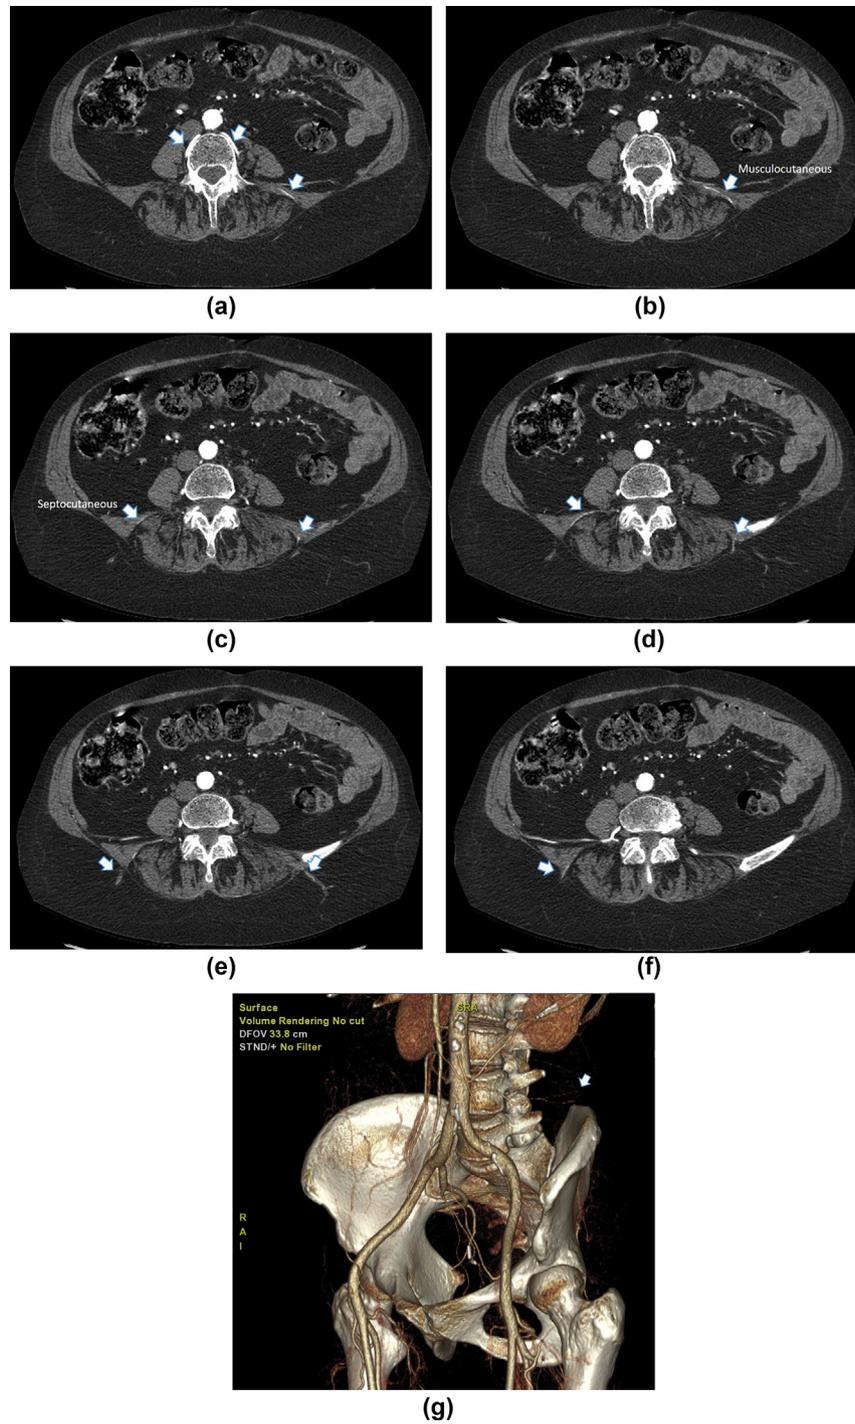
CTA of the abdomen. Axial images, arterial phase, arrows on images A to F follow the courses of same L4 arterial perforators on both sides of the body. A septocutaneous course is shown on the right side, while a musclocutaneous course is shown on the left side. (g) A 3D image. Imaging technique: The patient was positioned supine and scanned in the caudal to cranial direction. Contrast medium was injected intravenously with an 18 G needle placed antecubital using 140 ml iohexol (Omnipaque 350, GE Healthcare, Marlborough, MA, USA) followed by a 60 ml saline flush, both at an injection rate of 4 ml/s. Bolus tracking was utilized with a region of interest placed at the aortic bifurcation, 7 seconds delay from time of injector to contrast monitoring and 200 HU threshold for triggering. Images were acquired on GE HD750 (GE Healthcare, Waukesha, WI, USA) at 120 kVp, fixed 179 mA, 0.8 seconds rotation time, 64×0.625 collimation and 1.38 pitch. Generation of axial, sagittal, and coronal images were created from the 0.625 projection data using the manufacturer provided “standard” reconstruction kernel. A display field of view of 380 mm was used to create two axial series: 1.25 mm section thickness and 1 mm interval for detail and 2.5 mm section thickness and 2 mm interval for surveillance imaging. Maximum intensity projection (MIP) and 3D volume rendered (3D VR) images were generated on the Advantage Workstation server (version 3.2, GE Healthcare) using the 1.25 mm section thickness and 1 mm interval “standard” reconstructed images with anatomical coverage from the bottom of the kidneys through the pelvis. MIP images were created at 10 mm section thickness and 2 mm spacing for the axial, sagittal and coronal planes. The 3D VR images were post-processed using five degrees of rotation.
